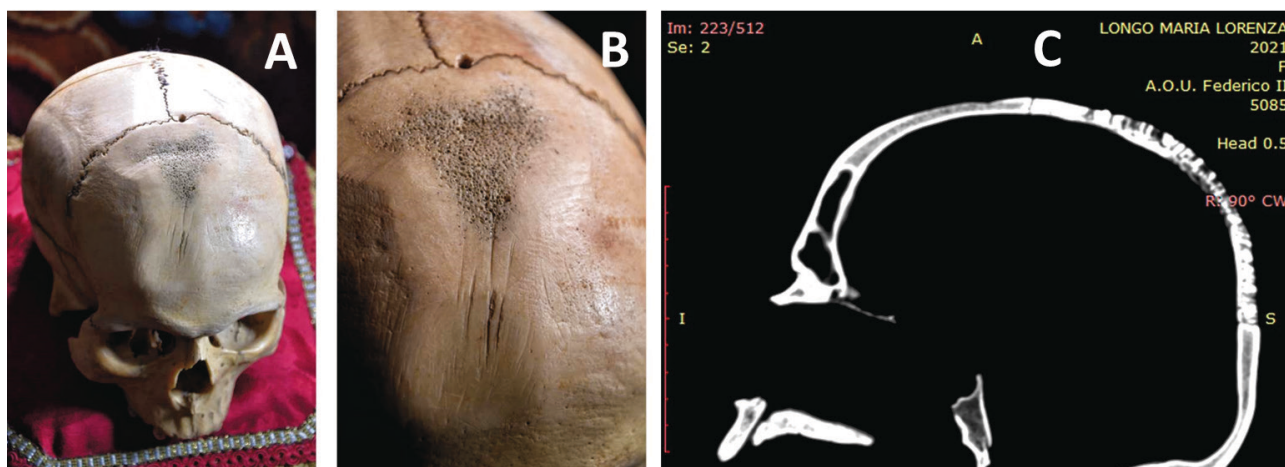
a: overall view of the postmortem damage affecting the anterosuperior aspect of the cranium; b: the detail of the mechanical damage on the frontal bone; c: sagittal CT view in which mechanical modification is evident on the cranium to the level of the diploe, and the absence of a physiological response.
